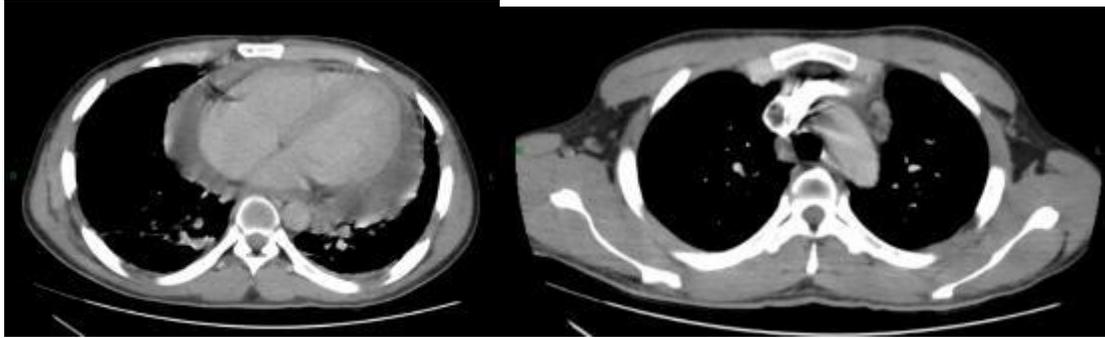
Thoracoabdominopelvic computed tomography showing a moderate pericardial effusion and non-necrotic mediastinal lymphadenopathy, the largest measuring 10 mm in short-axis diameter
